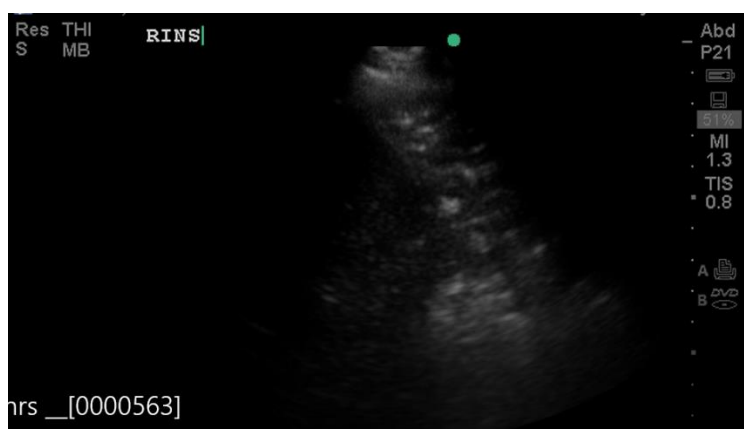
Consolidation as seen on lung ultrasound
